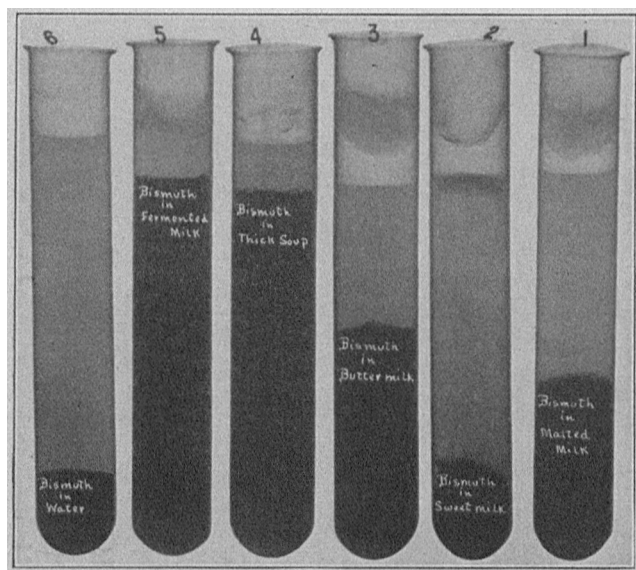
Radiograph of substances used for Röntgen-ray tests. Each test-tube contains an equal amount of bismuth subcarbonate. It shows the amount of settling fifty hours after suspension. 1. Malted milk and acacia. 2. Sweet milk. 3. Buttermilk. 4. Chicken soup. 5. Fermented milk. 6. Water and acacia. Note the remarkable stability of the suspension of the bismuth in the fermented milk.
